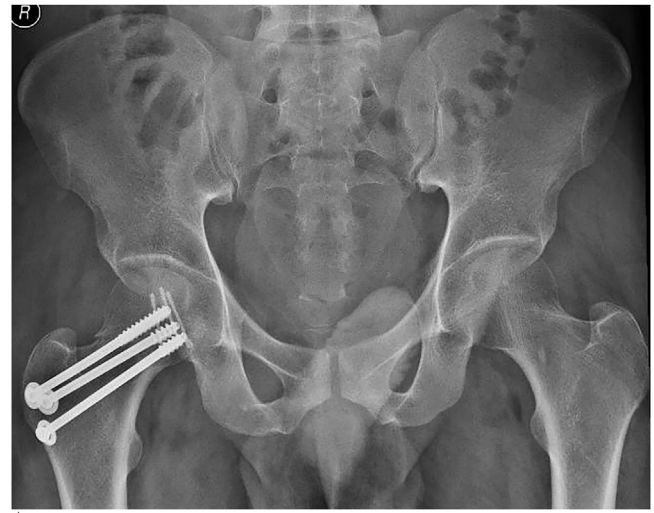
A. Anteroposterior radiograph of the pelvis at 6 weeks postoperatively. B. Anteroposterior radiograph of the pelvis at 15 months postoperatively showing subchondral lucency without joint changes.
